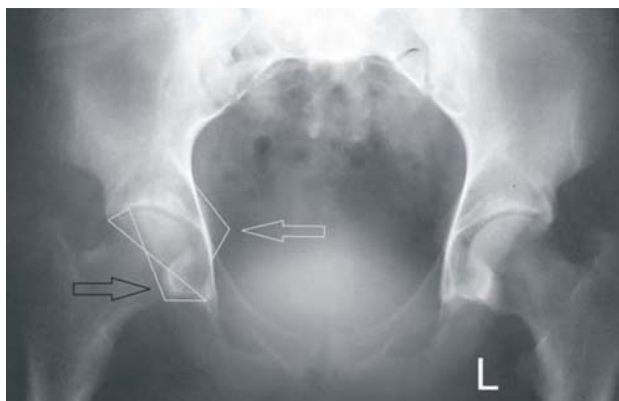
Standardized anteroposterior x-ray of the hips showing bilaterally positive sign of the ischial spine (white arrow), and acetabular retroversion (black arrow).
